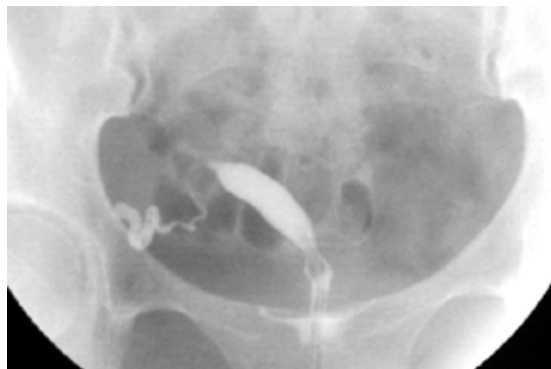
Unicornuate uterus. Hysterosalpingogram shows opacification of a single left uterine horn. The other uterine horn was rudimentary and was only visualised on ultrasonography.
